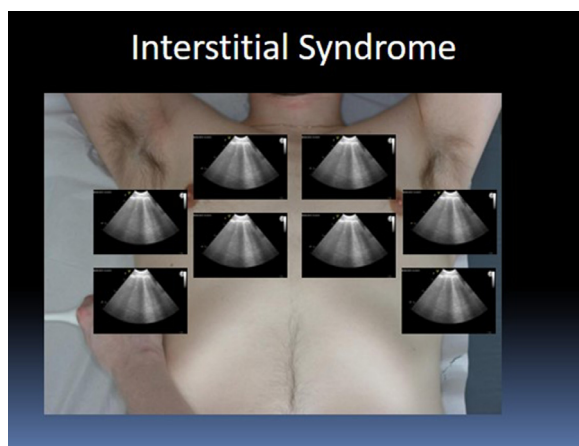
Picture suggestive of interstitial ultrasound syndrome with comets diffused throughout the chest.
